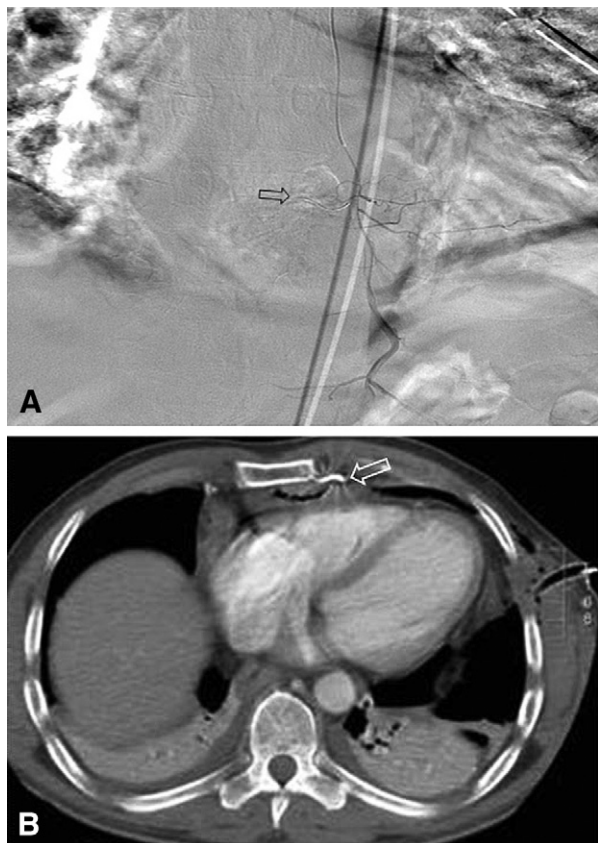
Transarterial embolization of a collateral branch of left mammary artery and screen shot angiography (A) along with computed tomography scan (B) 48 h after chest drain shows a complete bleeding control (arrow in A) and a reduction of the anterior mediastinal hematoma (arrow in B).
